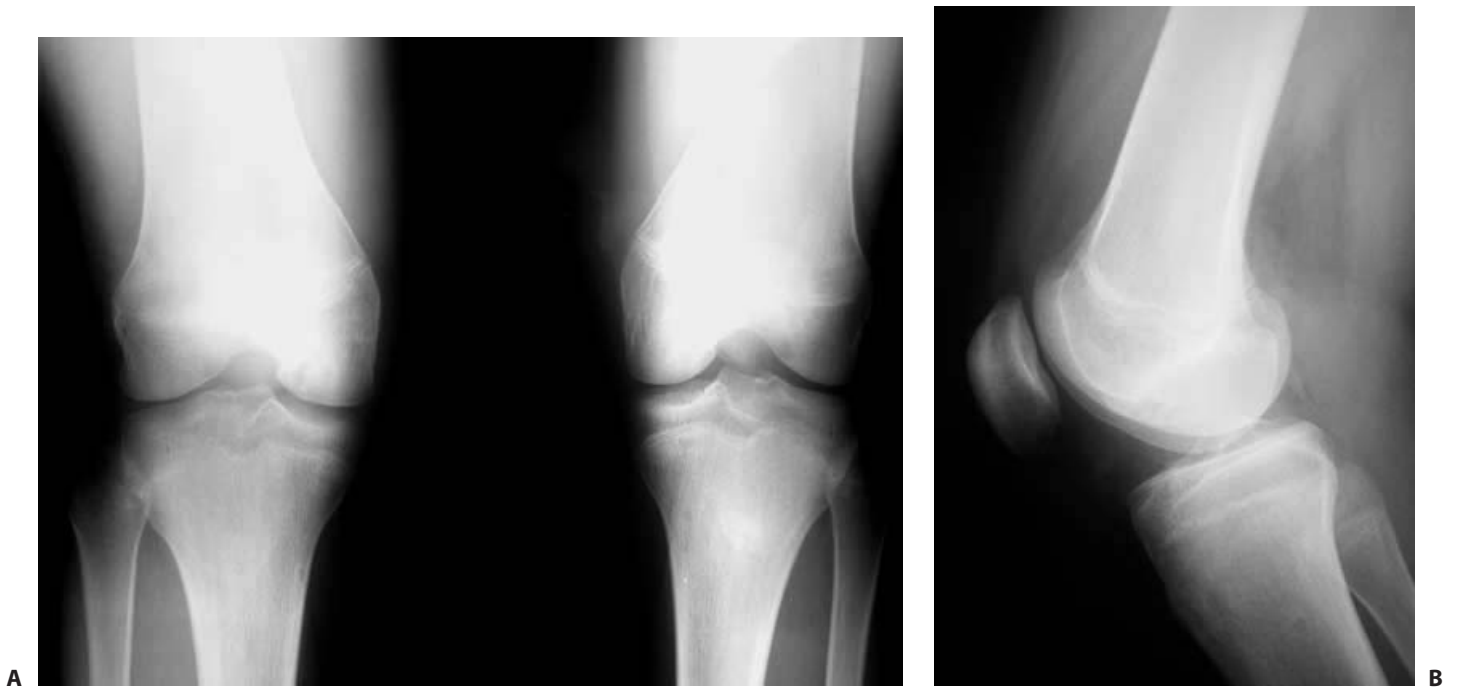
Six-month postoperative anteroposterior (A) and lateral (B) radiographs demonstrate integration of the fragment with no evidence of further fragmentation.
